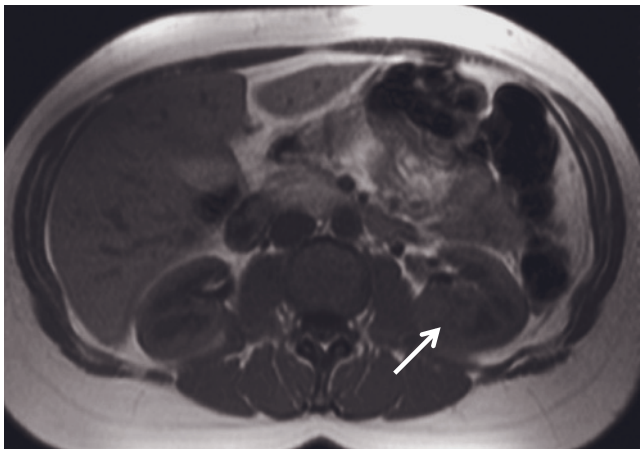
Lymphoma, diffuse infiltration. T1-weighted precontrast fat-suppressed SE (a), immediate postgadolinium SGE (b), and late-phase fat-suppressed gadolinium-enhanced SE (c) images. The right kidney is enlarged in a generalized fashion (a-c). CMD is not well shown on the precontrast T1-weighted image (a). On the immediate postgadolinium image (b), diminished enhancement of the renal cortex is present. However, the cortex has a normal thickness and uniformity. On the later interstitial-phase image, increased enhancement is present in the outer medulla, and multiple low-signal-intensity foci (arrows, c) are present in the inner medulla, which likely represent focal aggregates of lymphoma. (Reproduced with permission from Semelka RC, Kelekis NL, Burdeny DA, Mitchell DG, Brown JJ, Siegelman ES: Renal lymphoma: demonstration by MR imaging. *AJR Am J Roentgenol* 166: 823-827, 1996.) T1-weighted precontrast SGE (d) and 45-s (e) and 90-s fat-suppressed (f) postgadolinium SGE images in a second patient. The kidneys show decreased CMD on noncontrast T1-weighted images. There is also decreased, cortical enhancement on the 45-s postcontrast image, with heterogeneous medullary enhancement. The extent of renal enhancement shows negligible changes on the later postcontrast image.
